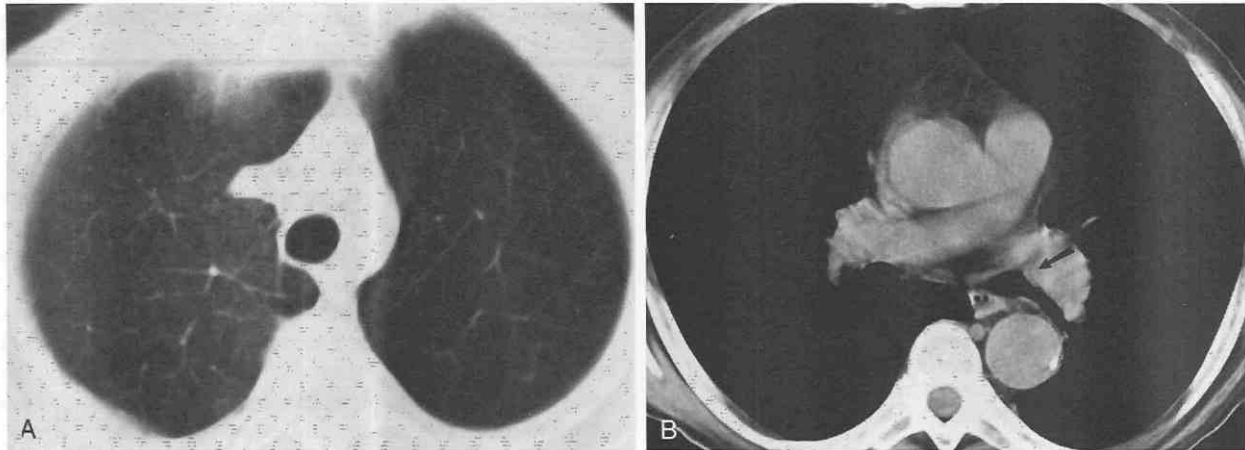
Squamous cell lung cancer with obstructive hyperinflation of the left upper lobe. A and B, CT scan shows hyperlucency of the left upper lobe and an endobronchial mass that completely occludes the left upper lobe bronchus (arrow in B).
